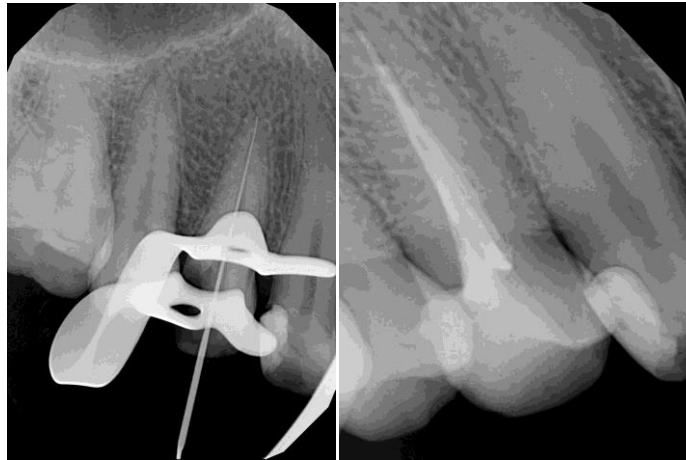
Periapical radiographs of tooth 14 a:preoperative, b:tooth length, c postoperative showing unacceptable density of root canal treatment " presence of voids "
